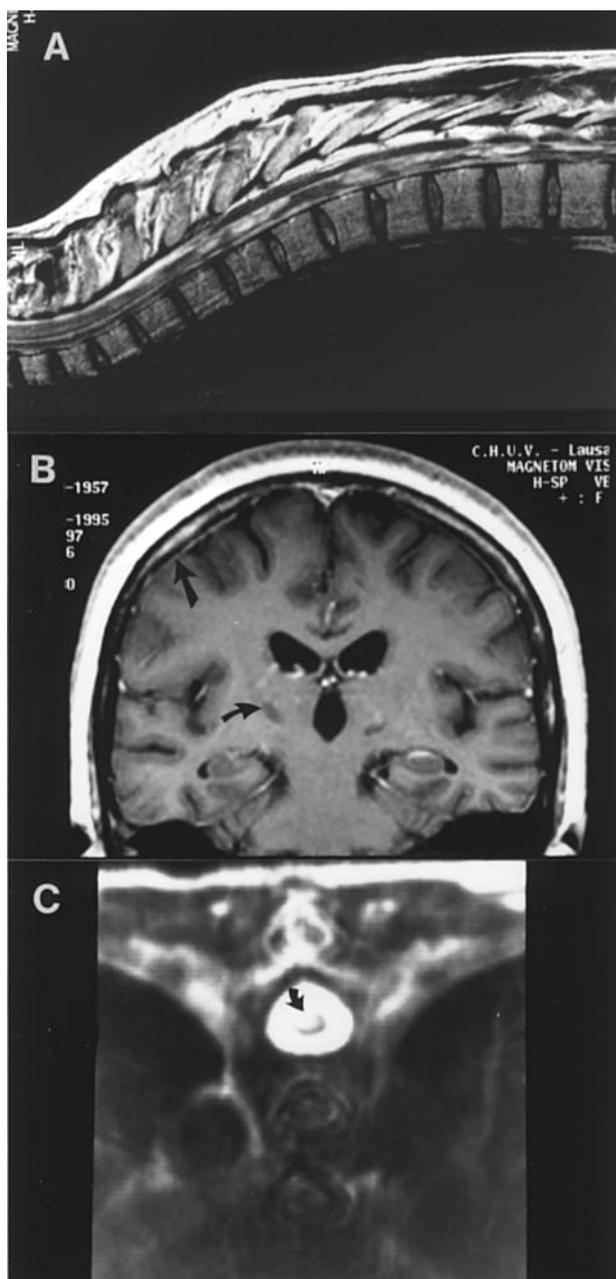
Nuclear magnetic imaging of central nervous lesions. (a) patient 1 T2-weighted sagittal cut of the spinal cord, showing disseminated hyperintense lesions in the cord. (b) Patient 2 T1-weighted coronal section, showing hypointense residual lesions of *Toxoplasma encephalitis* in the basal ganglia (e.g. curved arrow) as well as positive meningeal contrast enhancement (straight arrow). (c) Patient 3 T2-weighted transversal image of the cord at bone level T9, showing a hyperintense intramedullary lesion (arrow).
